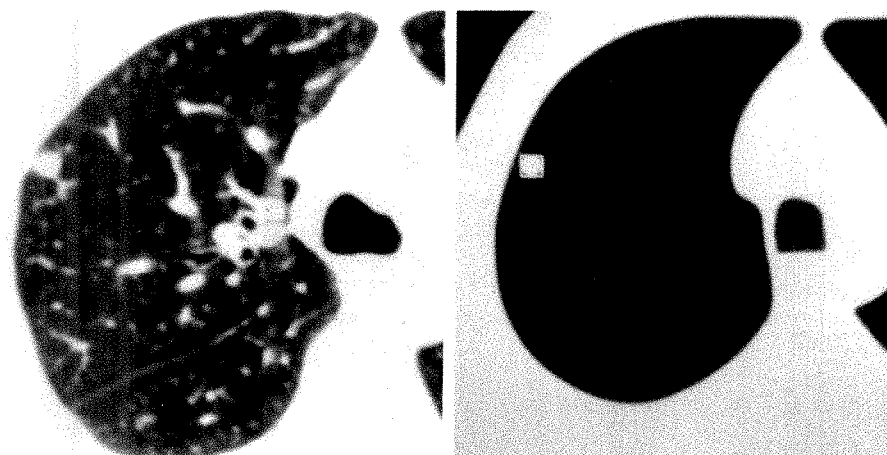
A, Thin, collimated CT scan reconstructed with standard algorithm in patient with a small nodule in right lung.
